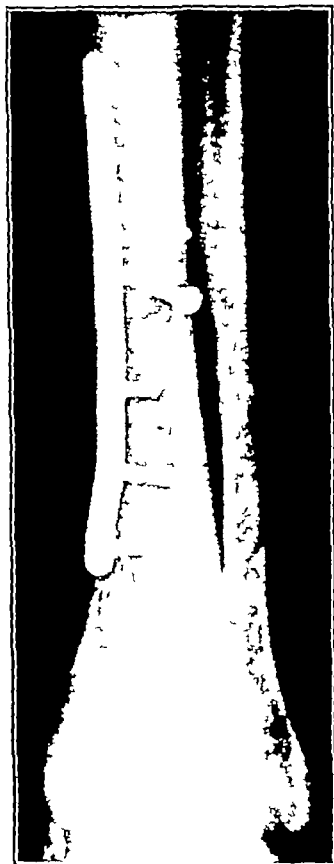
Postoperative roentgenogram of a fractured tibia treated with internal fixation by plate and screws
